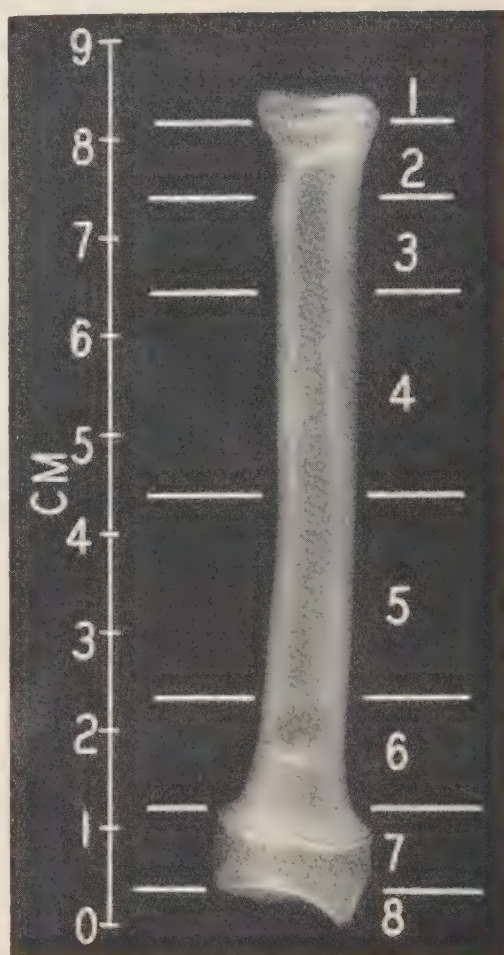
X-ray picture of left radius.
